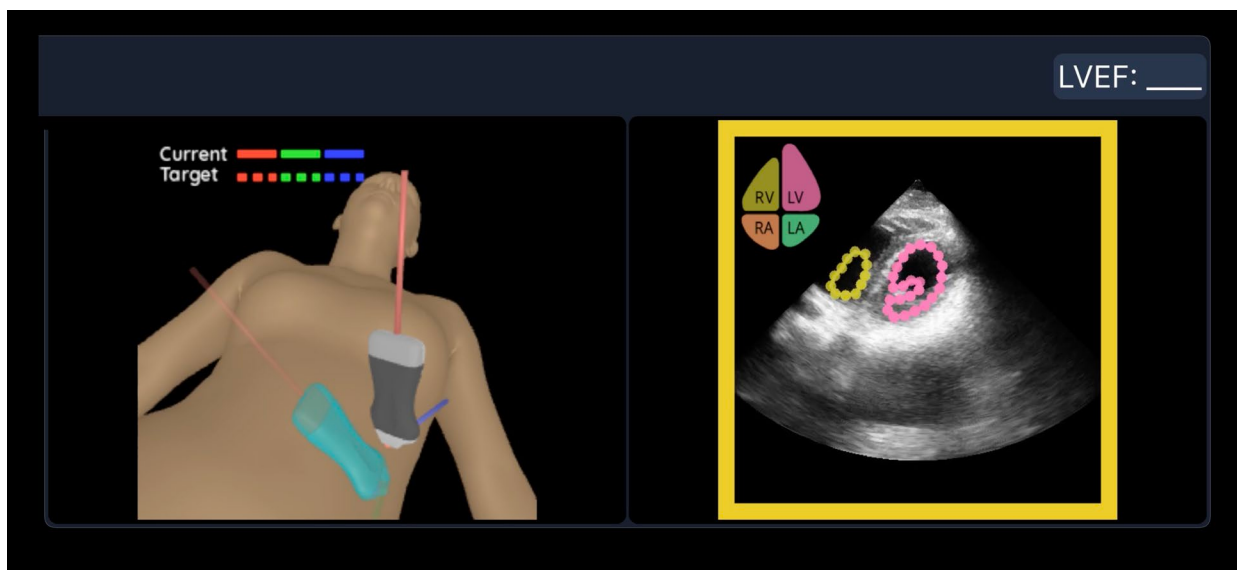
The clinician-facing cardiac guidance display (integration-test capture). Left: the 3D probe-guidance widget, with live probe and ghost target rendered on the patient's body mesh ("Current" and "Target" axes, drawn as solid, semi-transparent bars; the on-screen legend dashes the target only for clarity); the gap between them indicates direction and distance-to-goal. Right: annotated ultrasound, showing chamber-landmark contours with color legend (RV, right ventricle; LV, left ventricle; RA, right
